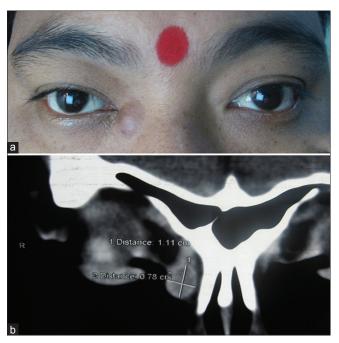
(a) Clinical photograph of the patient showing swelling medial to the right side medial canthus. (b) Computed tomography scan showing a mass of dimension 1.11 cm \times 0.78 cm over the lacrimal sac area
